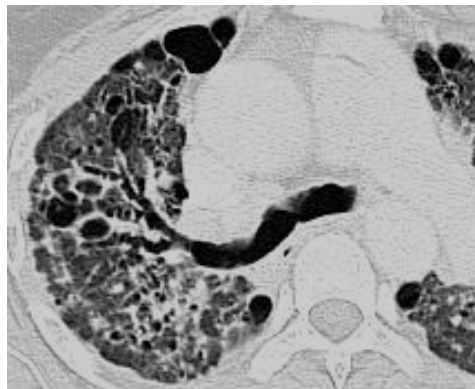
Axial CT, lung window at the level of right upper lobe bronchus shows bilateral air filled cavities with perivascular septa proved to be sarcoidosis.
